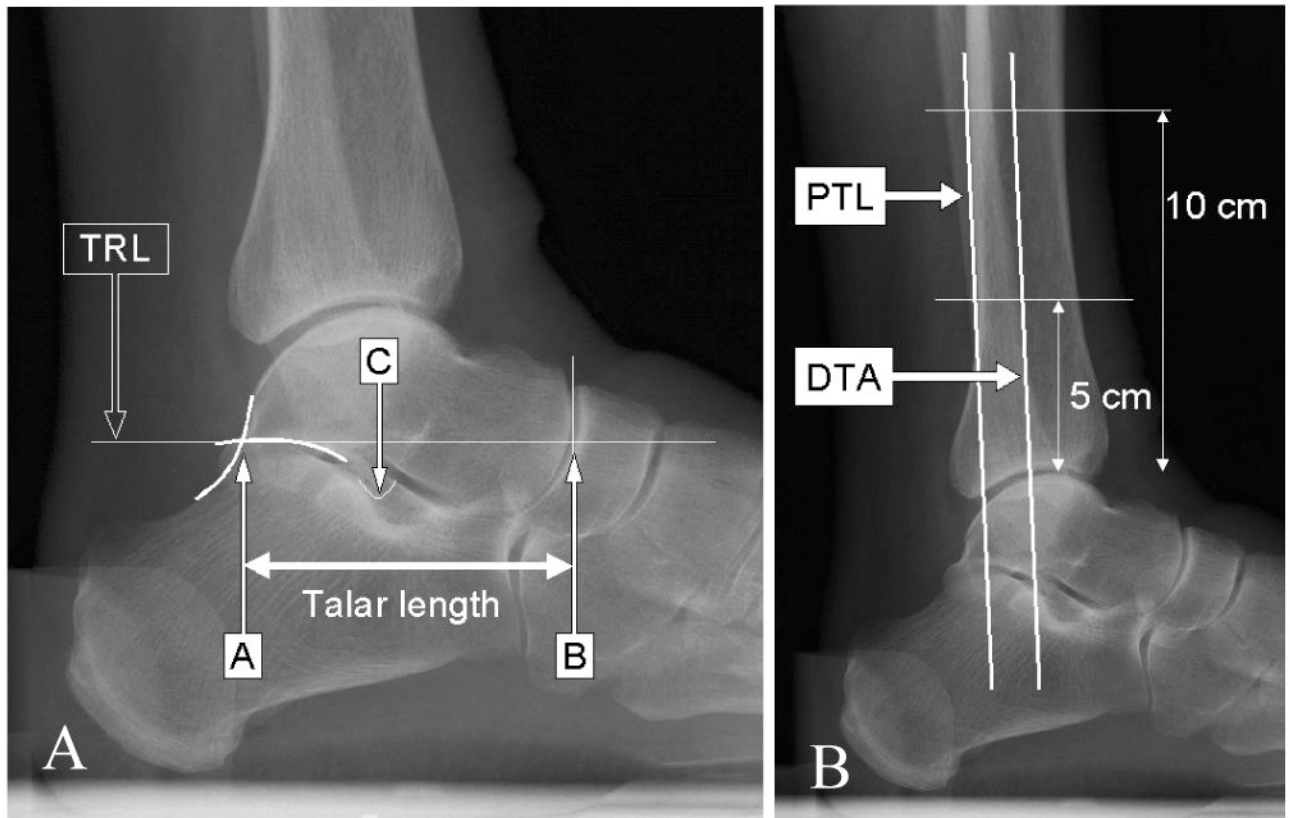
Radiographic landmarks. A) For the talus, the posterior talar point (point A) is identified as the intersection between the contours of the posterior subtalar articular surface and the postero-superior cortex of the calcaneus. The talar reference line (TRL) is a line drawn through point A parallel to the floor. Point B is identified as a vertical projection of the most anterior aspect of the talus onto the TRL, and length AB is the longitudinal talar length. Point C is the tip of the lateral talar process. B) For the tibia, the distal tibial axis (DTA) is a longitudinal mid-bisecting line of the distal tibial shaft determined at 5 and 10 cm above the ankle. The posterior tibial line (PTL) is a longitudinal line along the posterior tibial shaft surface, determined at those same heights.
